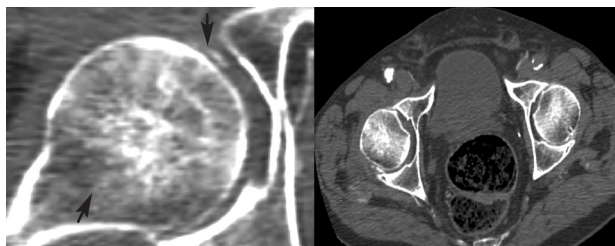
CT images showing evidence of chondrocalcinosis (arrows).
